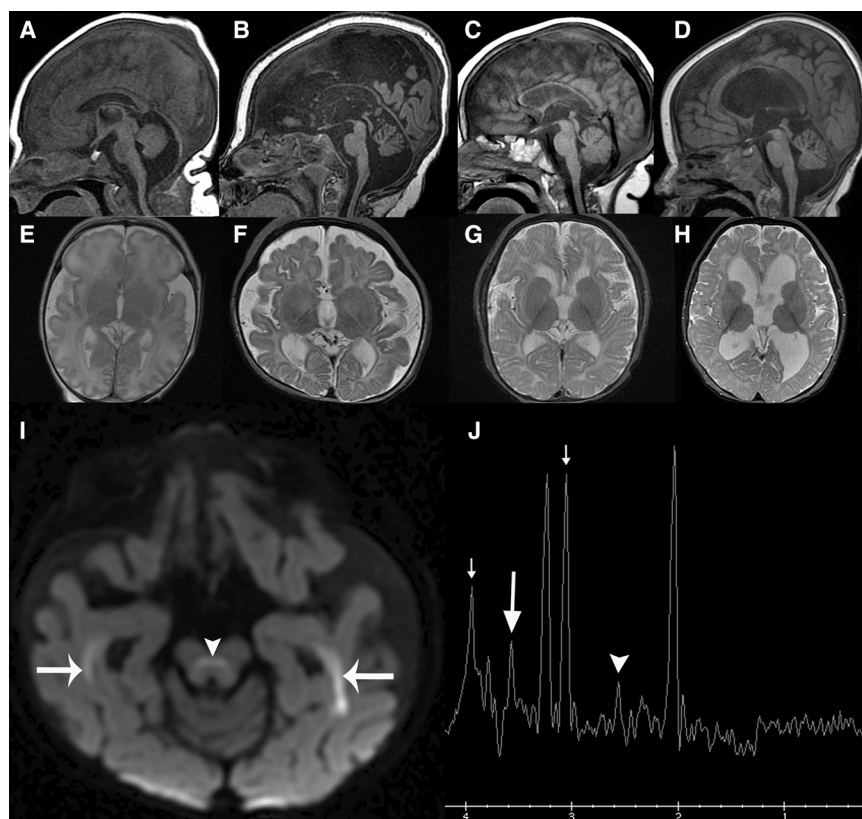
MRI Findings in Individuals with AARS Mutations
